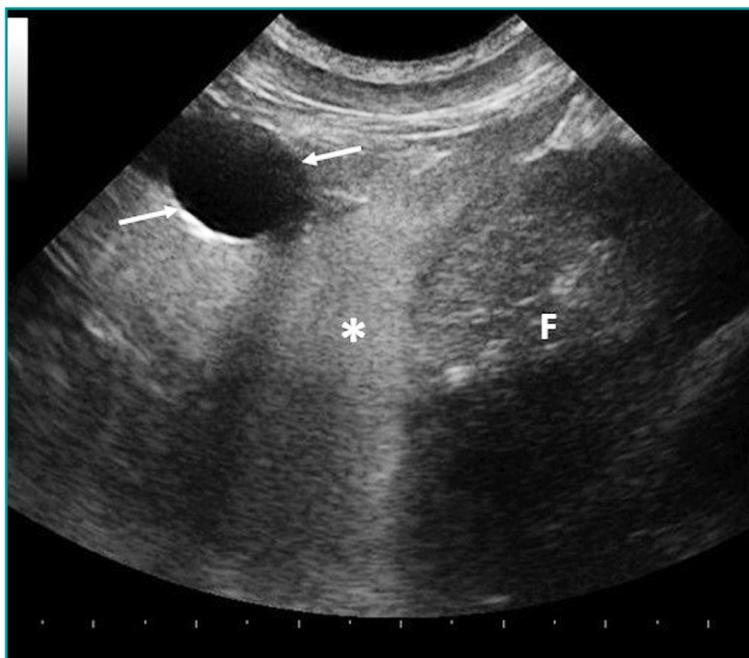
Ultrasound image obtained from the median longitudinal scan of the abdomen. Thin-walled anechoic cyst (arrows) cranial to the liver (L). The lesion appears surrounded by hyperechoic fluid (*).
